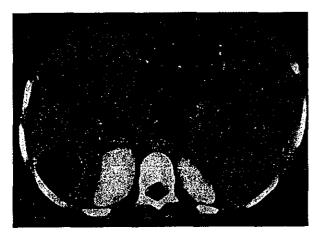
CT(7才入院時) S5,S 7に被膜を有する最大径39mmの低吸収性 腫瘍像を認めた.
